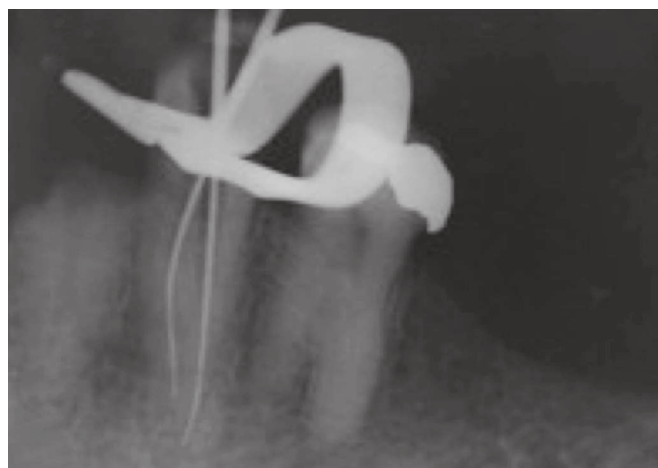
Main cones try-in radiograph.
